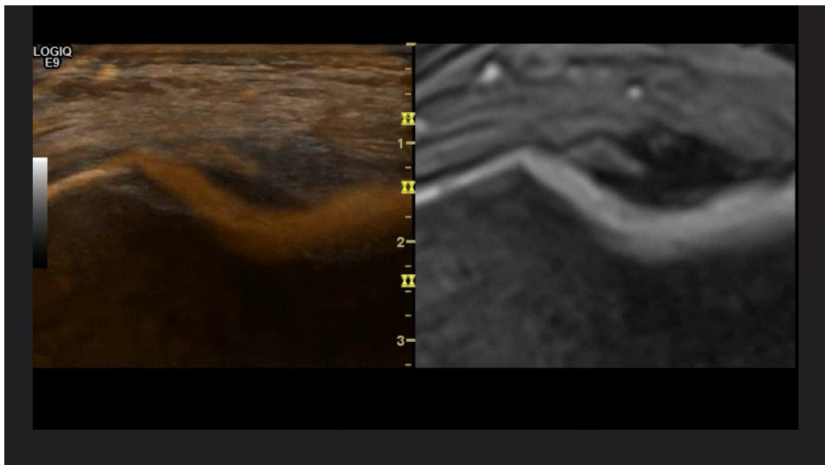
This is an example of a fusion of ultrasound (left) and an MRI axial view (right) in a trochlear groove following arthroscopic trochleoplasty.
